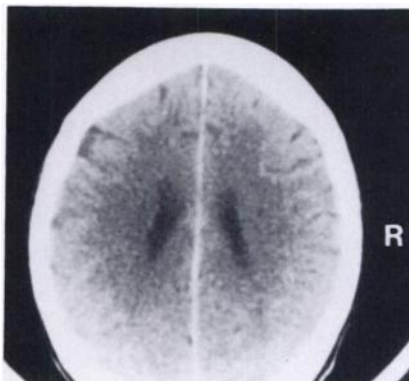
Cranial CT scan performed in the emergency department showing mild frontal atrophy.
